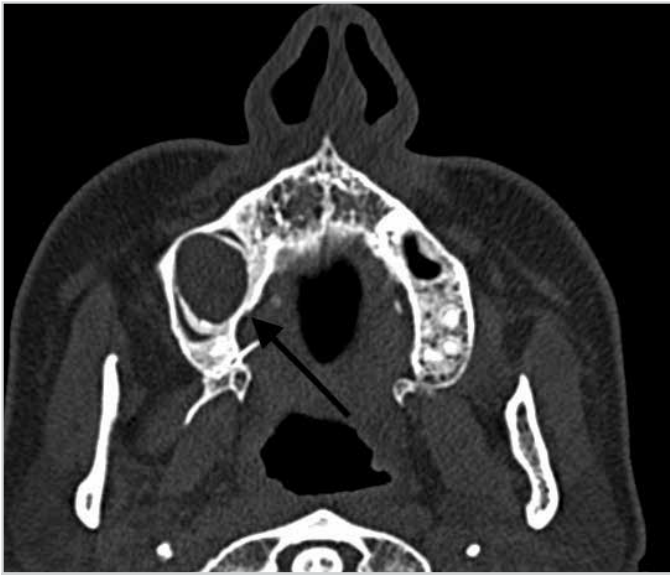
Axial paranasal computed tomography section showing a mass lesion
